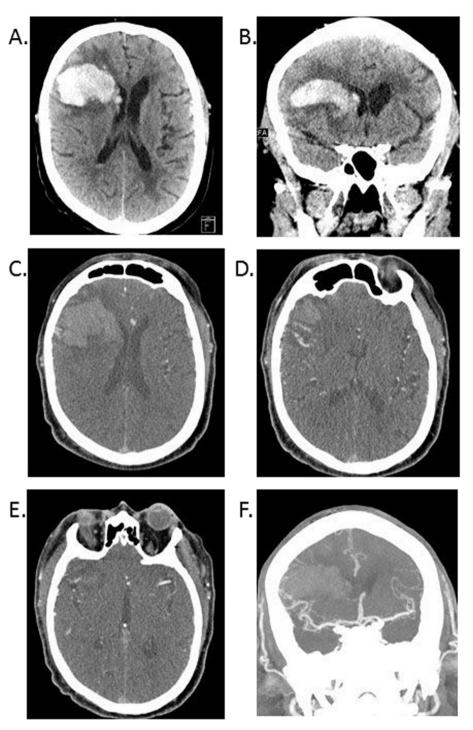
Axial and coronal unenhanced head CT images (A–B) show a right frontal parenchymal hemorrhage with intraventricular extent, partial effacement of the right lateral ventricle, sulcal effacement and mild leftward shift. Axial head CTA (C–D) shows prominent M2/M3 vessels within the right Sylvian fissure extending to a focus of irregular abnormal enhancement just lateral to the parenchymal hematoma in the peripheral right frontal lobe, most consistent with an AVM. There is a component of superficial drainage via a cortical vein overlying the right frontal lobe (axial CTA image) and arterial supply is predominantly from branches of the MCA (coronal MIP image).
